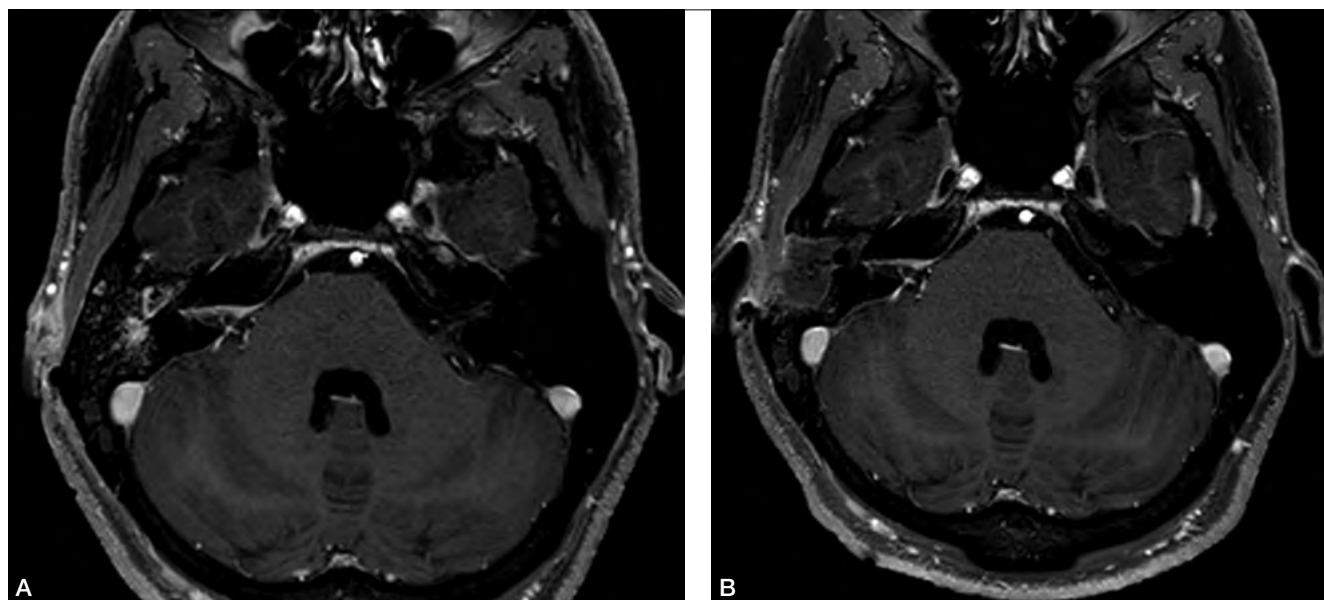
MRI, T1 sequence after gadolinium infusion, axial view, before surgery: clear reduction of the enhancement of the internal auditory canal; no more enhancement is visible at the level of the inner ear; B) control MRI, T1 sequence after gadolinium infusion, axial view, 3 months after the surgery: external and middle ear are packed with fat tissue; further reduction of the enhancement of the internal auditory canal.
